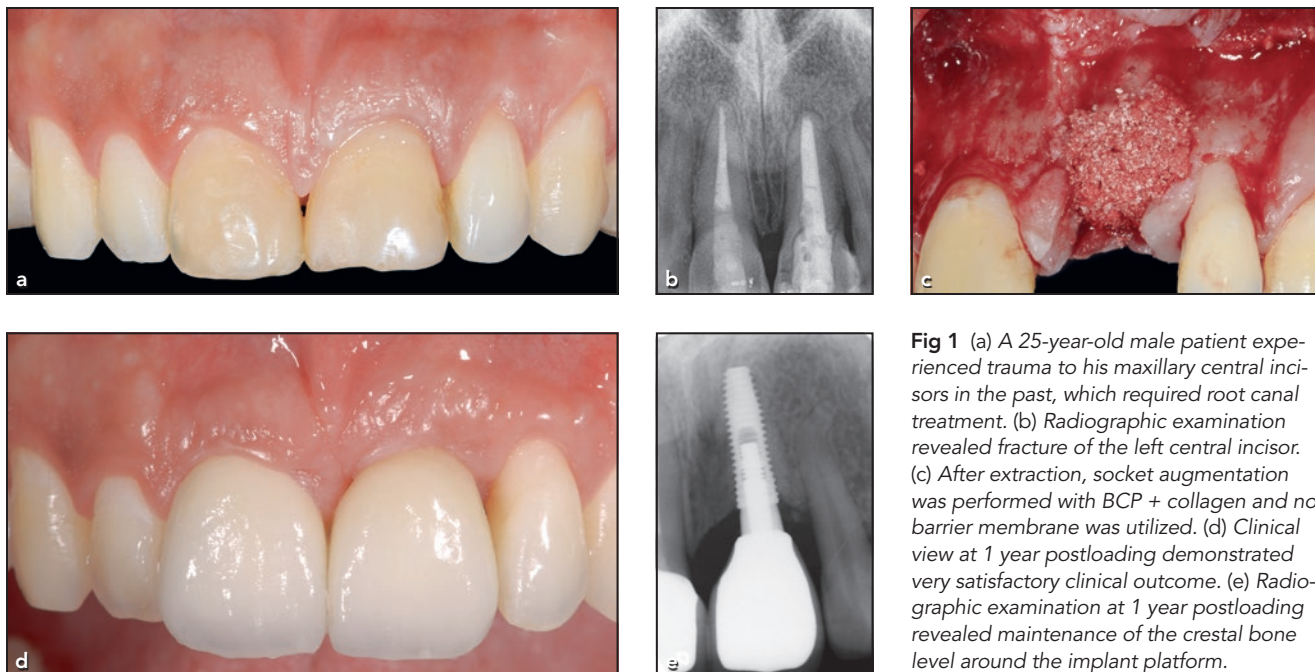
(a) A 25-year-old male patient experienced trauma to his maxillary central incisors in the past, which required root canal treatment. (b) Radiographic examination revealed fracture of the left central incisor. (c) After extraction, socket augmentation was performed with BCP + collagen and no barrier membrane was utilized. (d) Clinical view at 1 year postloading demonstrated very satisfactory clinical outcome. (e) Radiographic examination at 1 year postloading revealed maintenance of the crestal bone level around the implant platform.
